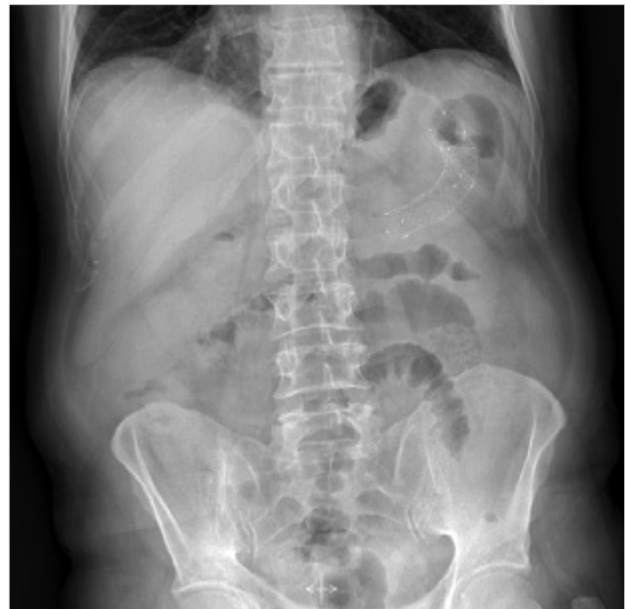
Location of the stent on the upright abdominal X-ray following endoscopic stent placement for a left flexure tumor
